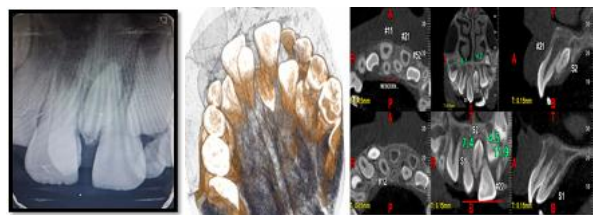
Intraoral periapical radiograph and Cone beam computed tomography showing the erupted mesiodens and an impacted mesiodens located between the permanent maxillary central incisors.
